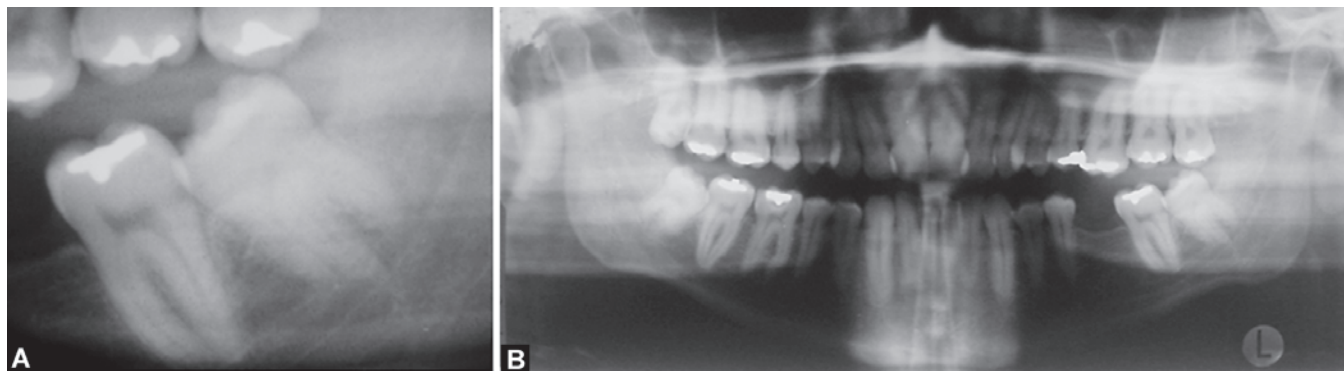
A and B: (A) Periapical X-ray of an 18-year-old man showing impacted 38. Even though the X-ray is of good quality, only one mesial and one distal root is visible, (B) Surgical removal of tooth was difficult and the extracted tooth showed four roots
